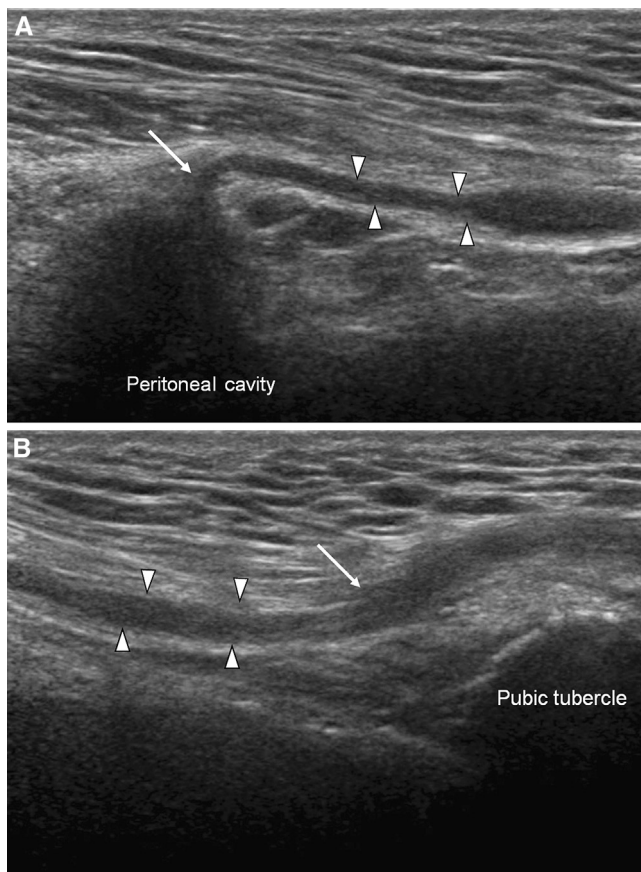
(A) Deep inguinal ring; oblique longitudinal sonogram along the inguinal canal, showing spermatic cord (arrowheads) within the proximal inguinal canal, which lies superior to the inguinal ligament; the spermatic cord passes through the deep inguinal ring (arrow), lateral to the inferior epigastric vessels to reach the peritoneum. (B) Superficial inguinal ring; oblique longitudinal sonogram, showing the spermatic cord (arrowheads) within the inguinal canal, extending through the superficial inguinal ring (arrow) to reach the high scrotal area (not shown here).
